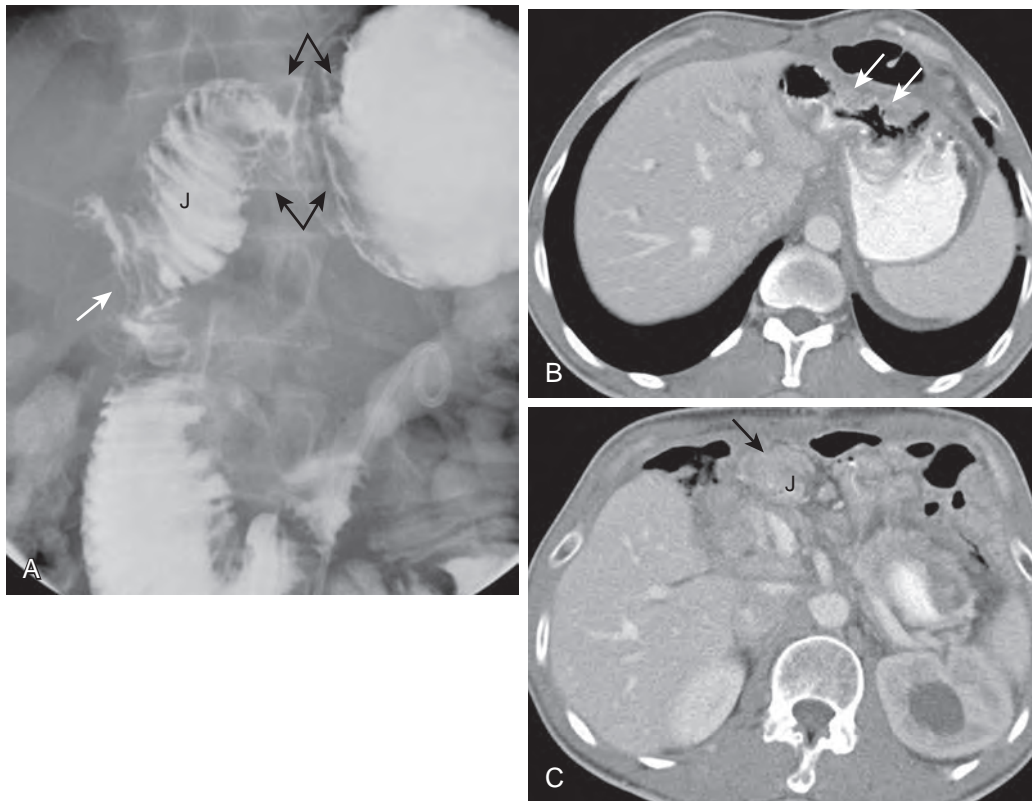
Recurrent tumor following distal gastrectomy for gastric cancer. A. Supine UGI image shows thickened, lobulated folds along the distal gastric remnant and gastrojejunal anastomosis (*black arrows*). There are also tumor implants (*white arrow*) along the jejunal limb (J). B, C. Axial contrast-enhanced CT scans show lobulated soft tissue along the distal gastric remnant (*white arrows*) caused by tumor recurrence. Also note a tumor implant (*black arrow*) along the jejunal limb (J).
